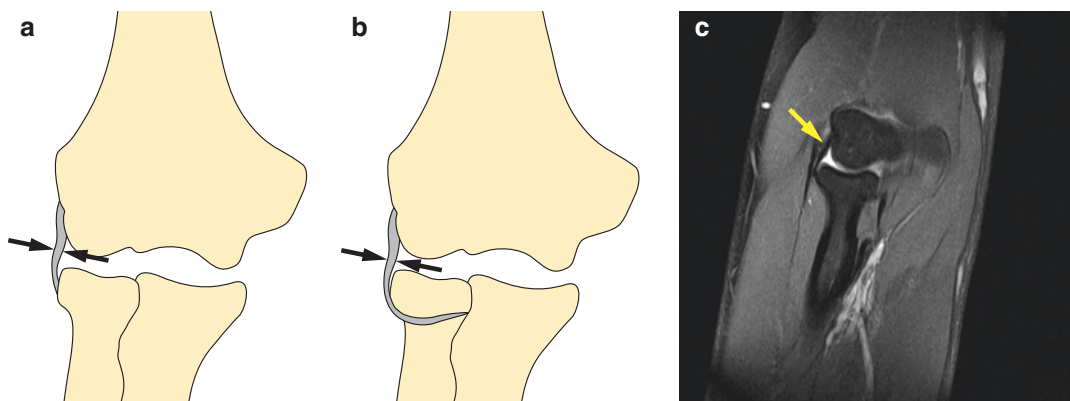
The RCL in the coronal plane (a) and the lateral UCL (b) which attaches to the supinator crest of the ulna. A coronal MRI 3-D (True FISP) image showing the RCL deep to the common extensor tendon (c)
